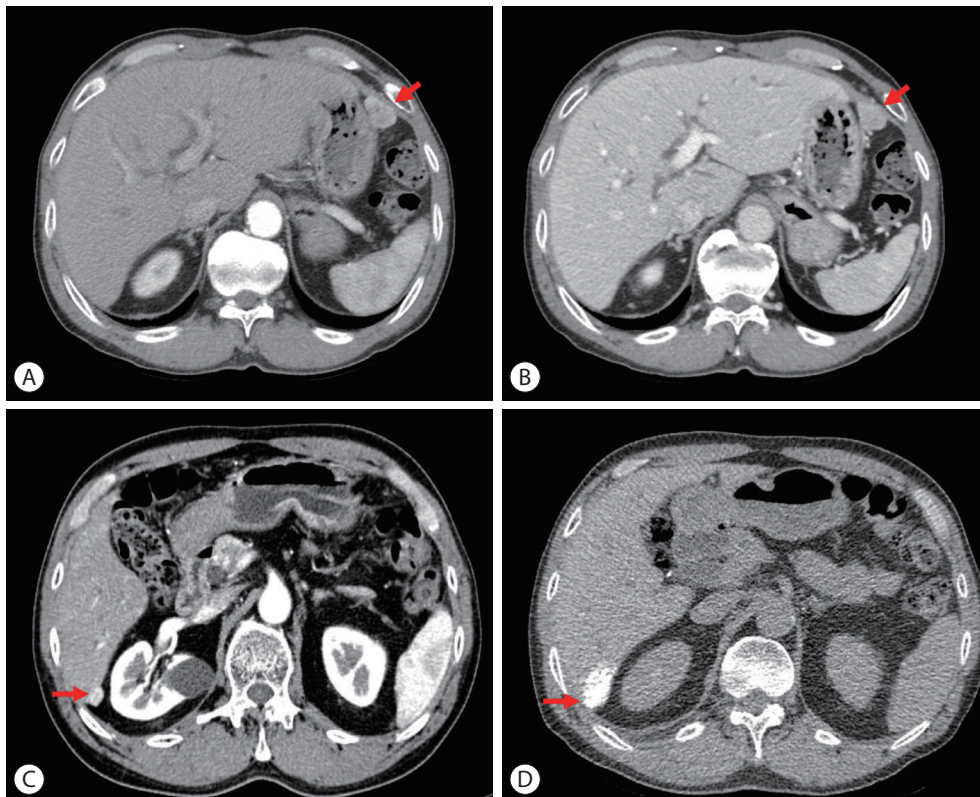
Initial and follow-up liver dynamic computed tomography (CT) imaging findings. (A) Arterial and (B) portal phase on July 2012, 3.5 cm single nodular hepatocellular carcinoma (HCC) on S3 (red arrow). (C) Arterial phase, before transarterial chemoembolization (TACE) on May 2014, 1.5 cm recurrent HCC on S6 (red arrow). (D) Lipiodol uptake (red arrow) on non-contrast CT after TACE on July 2014.
